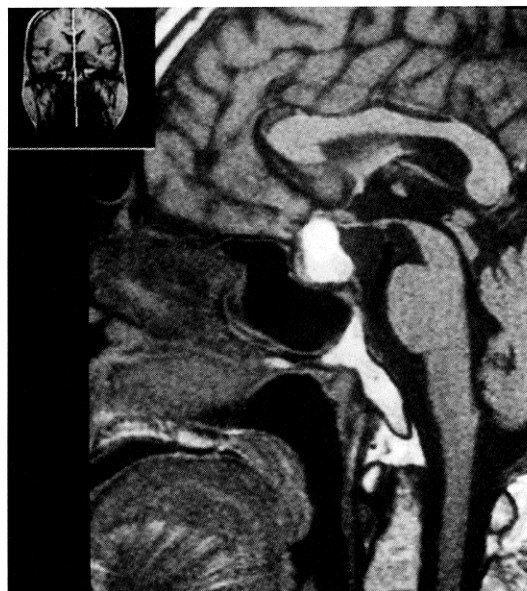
Sagittal T₁-weighted MR images showing a high intense intra- and suprasellar mass and a focal iso-intense component in the postero-inferior part of the lesion.
